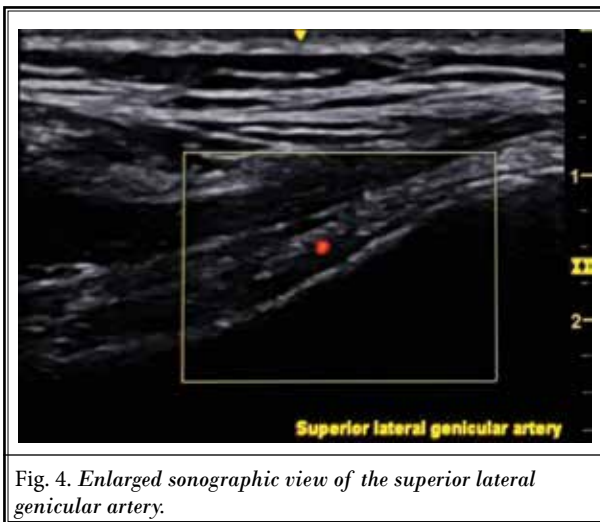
Enlarged sonographic view of the superior lateral genicular artery.
